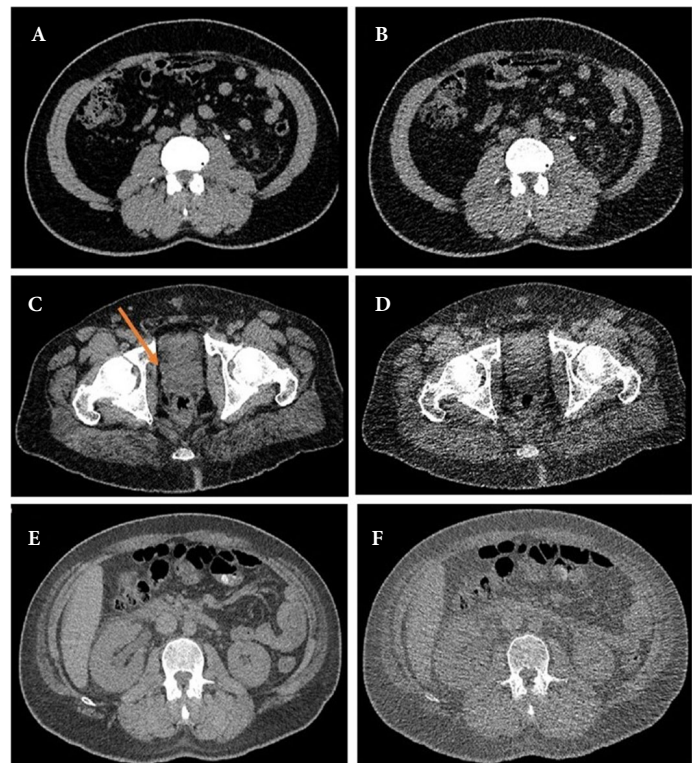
Comparison of standard-dose CT (Panels A, C, E) and ultra-low-dose CT (Panels B, D, F) imaging to demonstrate difference in imaging quality when assessing for ureteric calculus (A, B), hydronephrosis (C, D), and parenchymal lesions (hypodense structure on posteromedial lip of right kidney, arrow; E, F).
